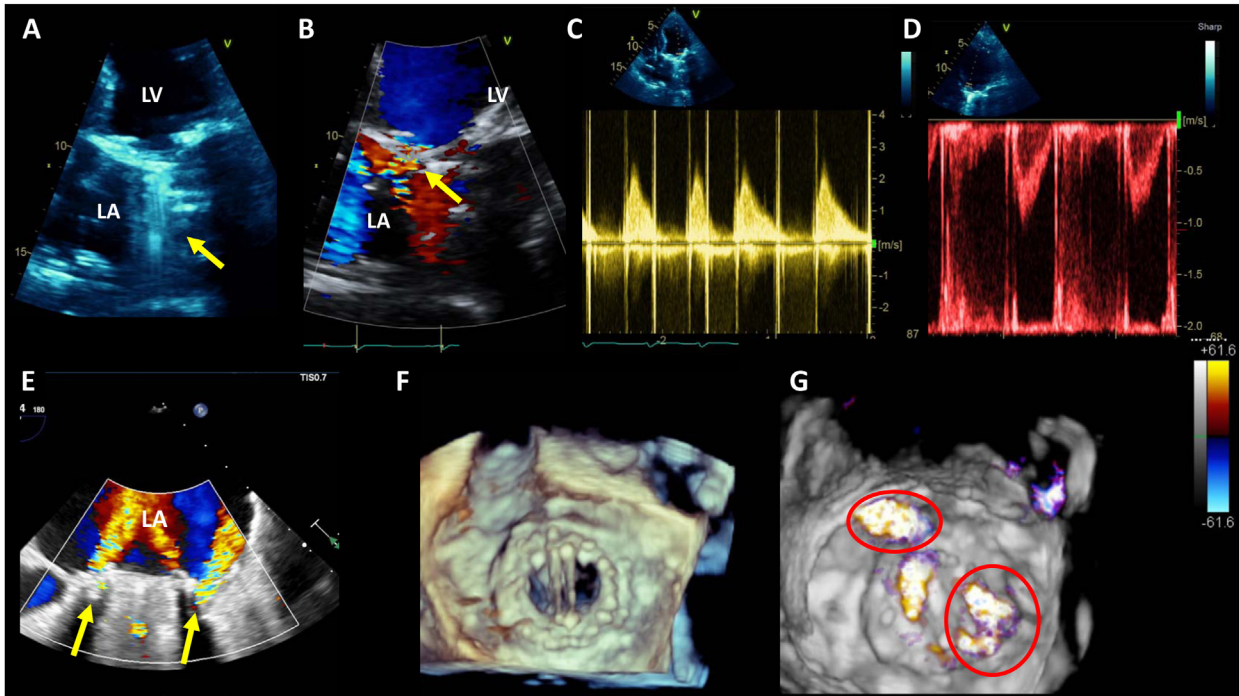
A case of paravalvular MR in a mechanical valve. (A) Apical four-chamber view shows acoustic reverberation behind the mechanical mitral valve (MV) in systole (*arrow*). (B) Color Doppler shows eccentric MR (*arrow*); artifact makes its origin and extent difficult to ascertain. (C) Spectral Doppler shows elevated velocities and gradient across the valve (mean gradient, 9 mm Hg at a heart rate of 87 beats/min) with VTI_{MV} of 52 cm. (D) Spectral PW Doppler in the LVOT shows reduced velocity and VTI of 17 cm. A ratio of prosthetic MV VTI to VTI_{LVOT} of 3 alerts to the presence of concomitant regurgitation in the absence of mitral stenosis inferred from a normal PHT. (E) Midesophageal TEE shows two paravalvular regurgitant jets (*arrows*). (F) Three-dimensional TEE shows a wide-open valve in diastole. (G) Three-dimensional TEE with color shows two PVLs, one at 11 o'clock and the other at 5 o'clock (*circles*). The third more central jet is a washing jet, as seen in (E). LA, Left atrium; LV, left ventricle
